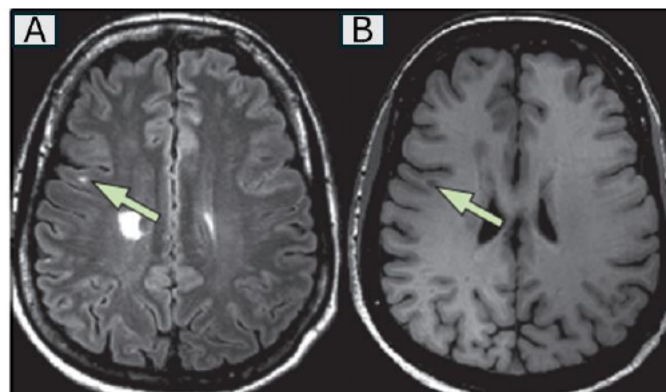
MRI as a tool for MS diagnosis.
